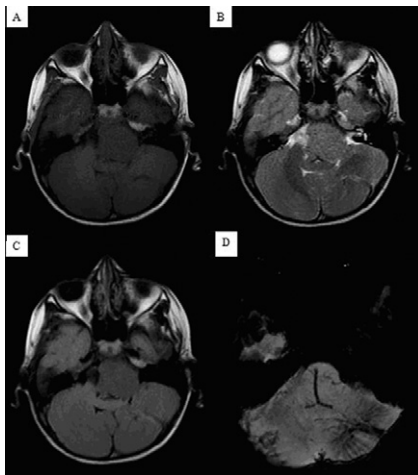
Seven year old male patient investigated for left CPA mass. Apart from the left CPA mass lesion. T1 (A), T2 (B) and FLAIR (C) images incidentally show an ill-defined linear structure in the left cerebellar hemisphere, SWI minIP (D) images clearly demonstrate the venous angioma (arrow) in the left cerebellar hemisphere with its characteristic medusa head appearance.
